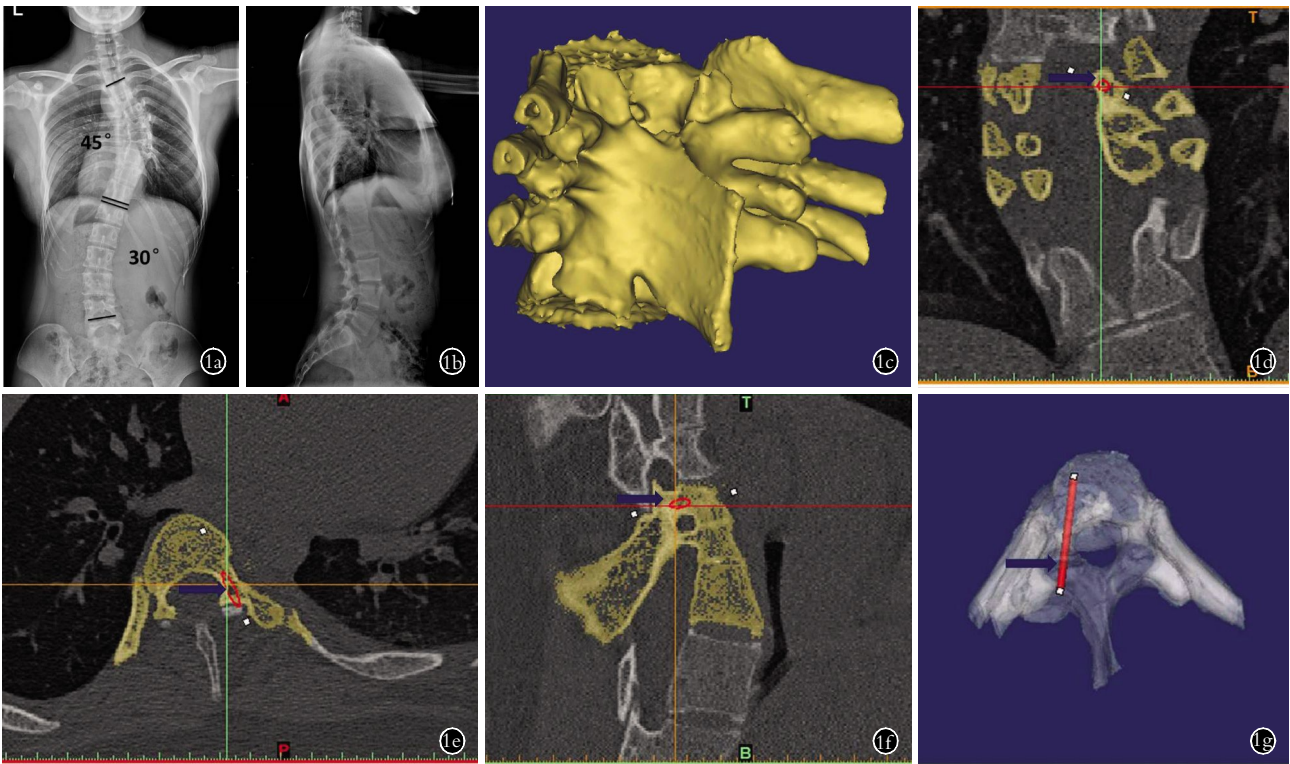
患者,女,14 岁,先天性脊柱侧凸 1a. 脊柱全长正位 X 线片显示 T₆-T₇ 和 T₇-T₈ 未分节,主弯 Cobb 角 45° 1b. 侧位 X 线片显示胸椎前凸 1c. CT 扫描后,应用软件将每个节段独立分割并行三维重建,本例 T₇-T₈ 节段因未分节,视为同一节段进行设计 1d, 1e, 1f, 1g. 进行模拟置钉,分别在冠状位(1d)、轴位(1e)及矢状位(1f)上调整虚拟螺钉位置,并在三维视图(1g)上进一步确认,其中虚拟螺钉为红色,蓝色箭头所示为虚拟螺钉位置
